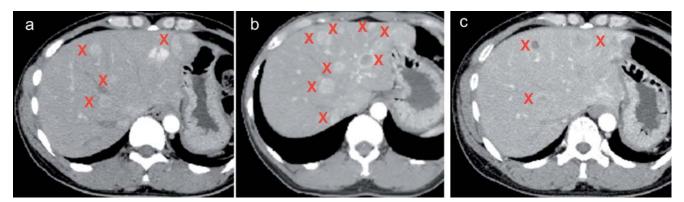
Abdominal computed tomography showing recurrent disease in the liver. (a) pretreatment, (b) after chemotherapy, (c) after sunitinib treatment. X: tumor occupied region.
